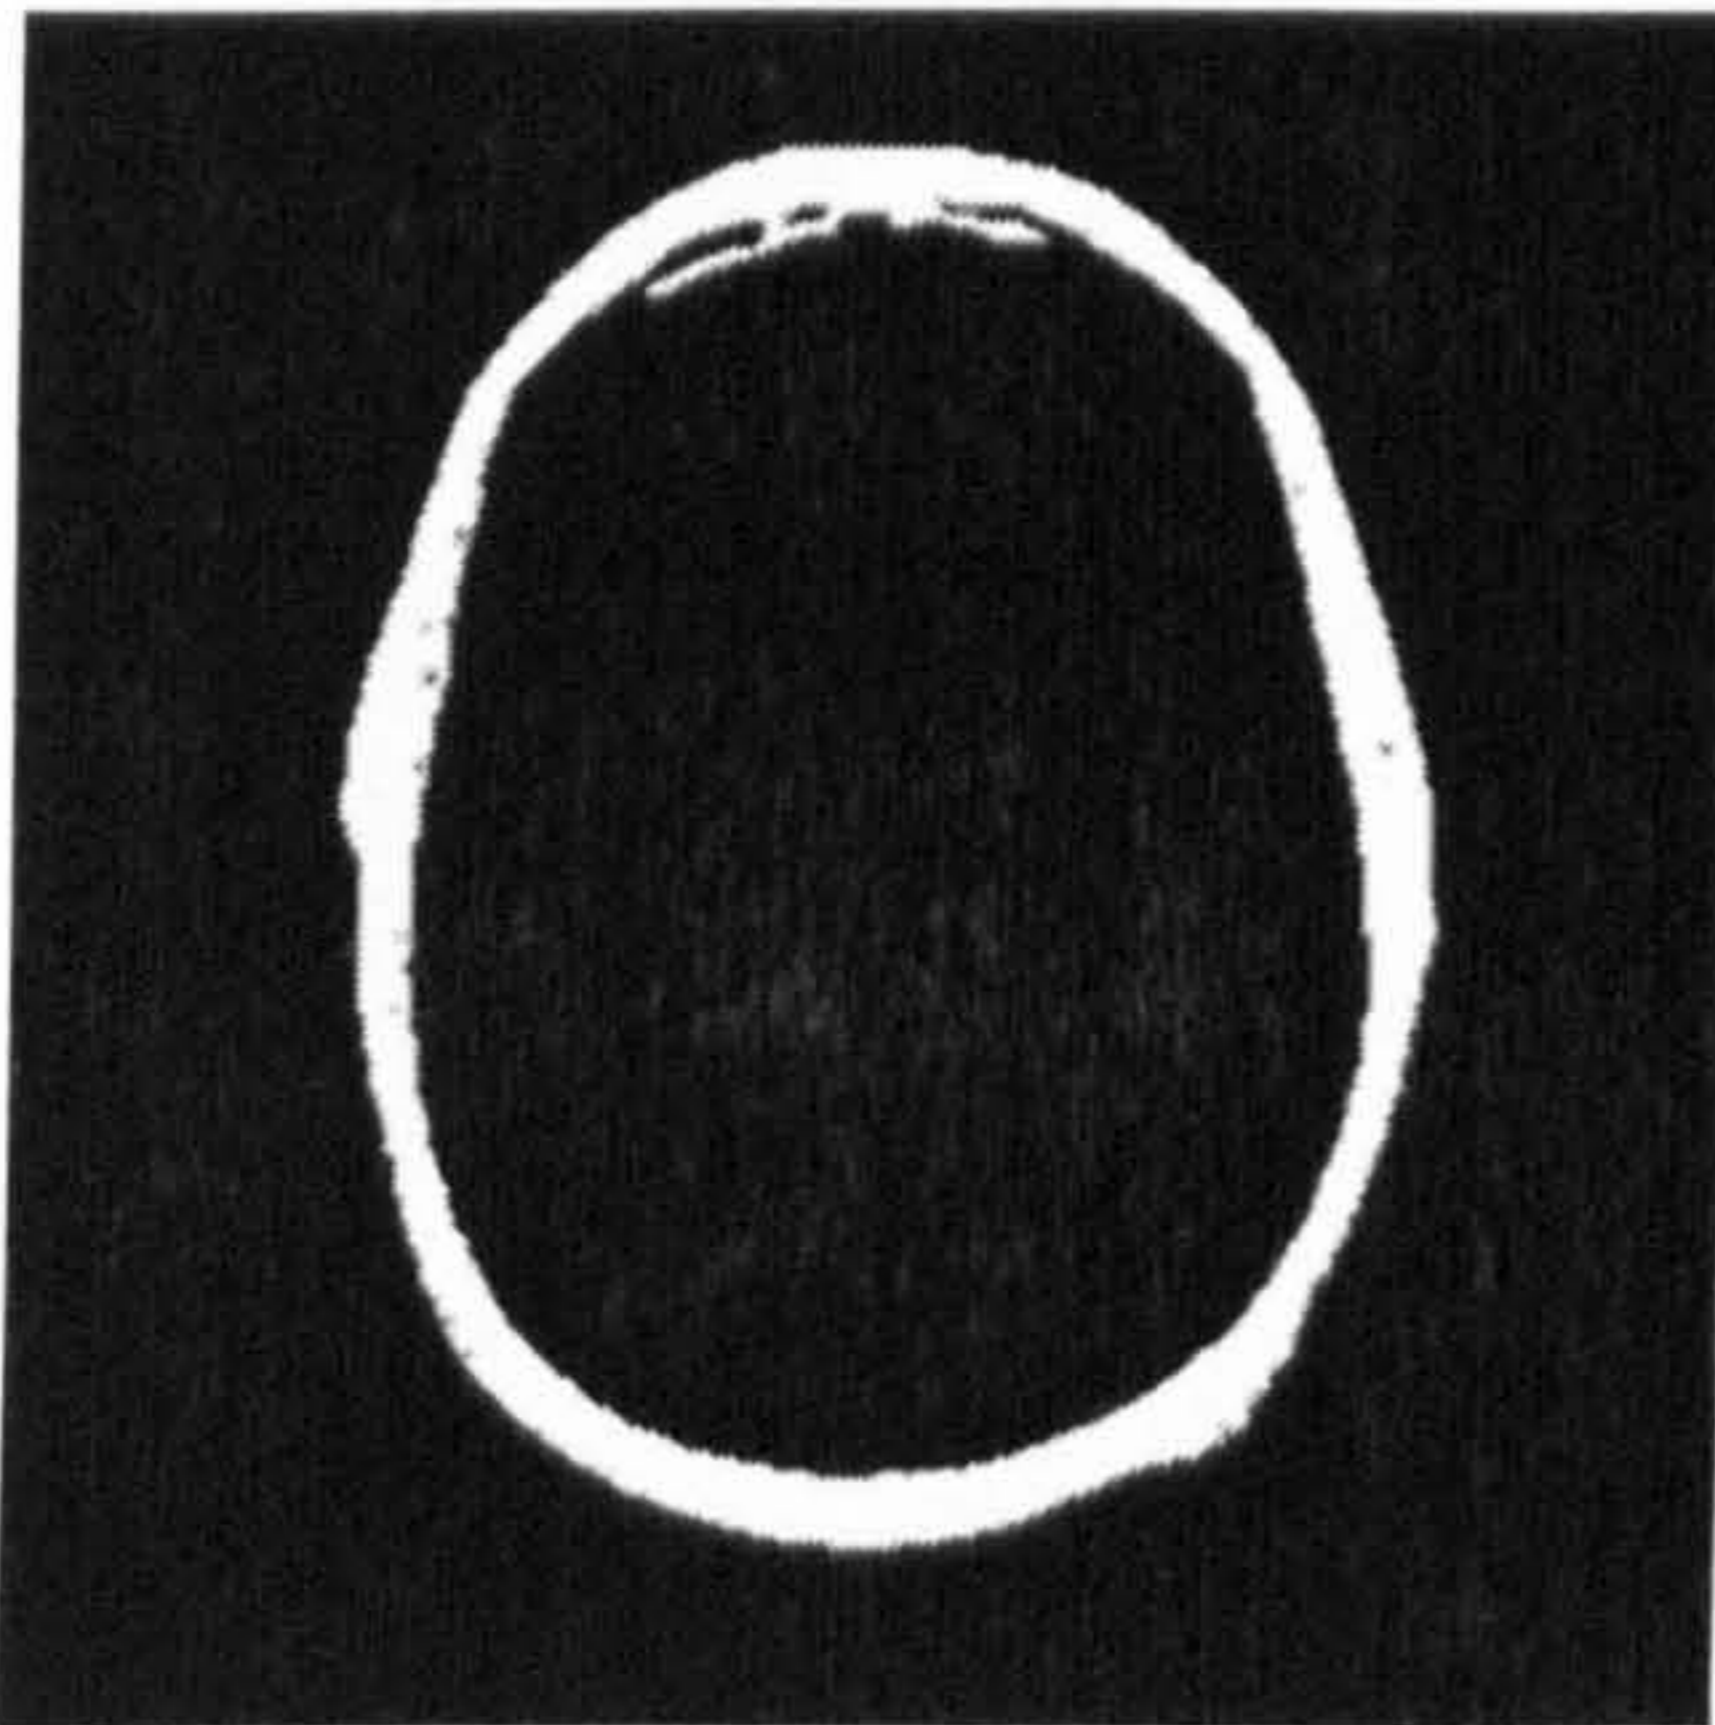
Preprocessing and segmentation of FLAIR-FSE MR image.
